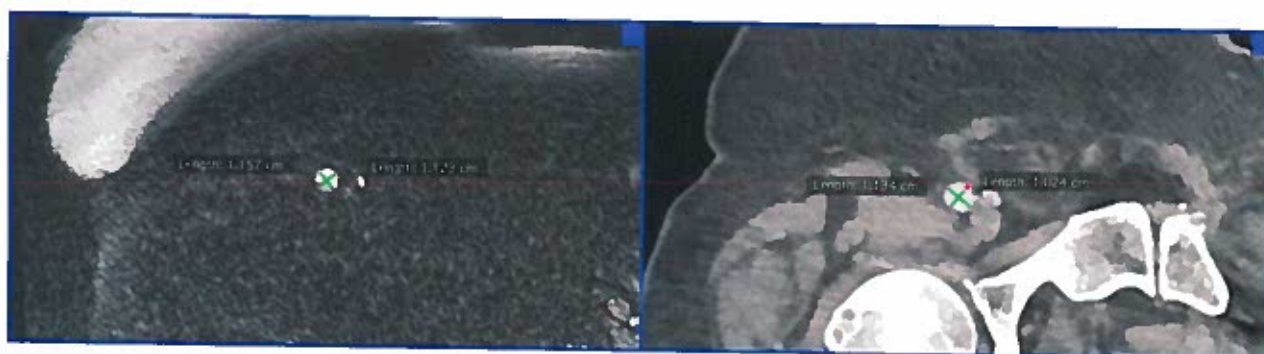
QISS MRA and CTA at the level of the right common femoral artery demonstrating similar measurements.
